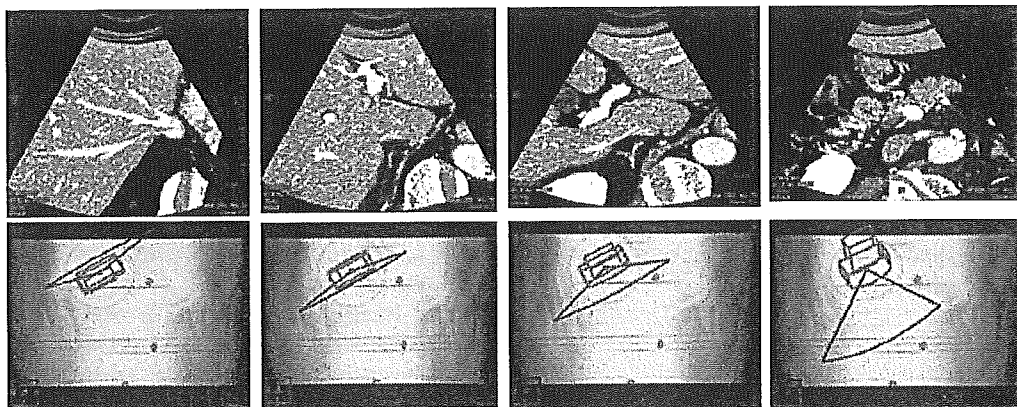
Continuous scanning for virtual ultrasonography. Slices are reconstructed from various angles, with each slice continuously animated as in conventional US.
